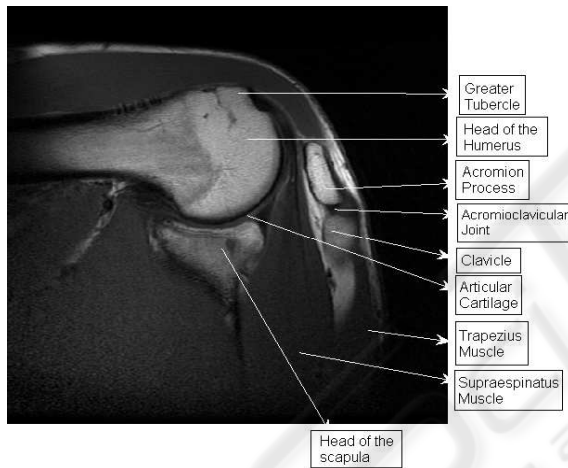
Components of the shoulder, Coronal MR image.
